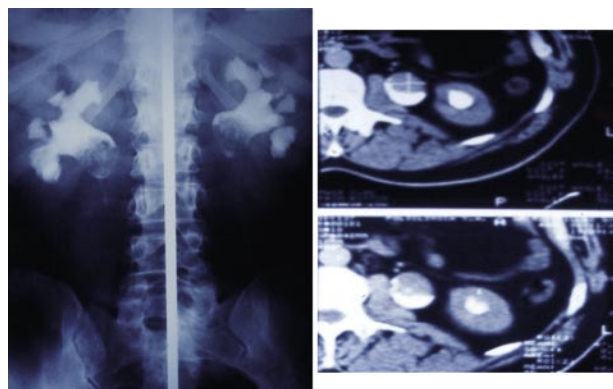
Diagnosis with intravenous urography and abdominal-pelvic CT scan.
